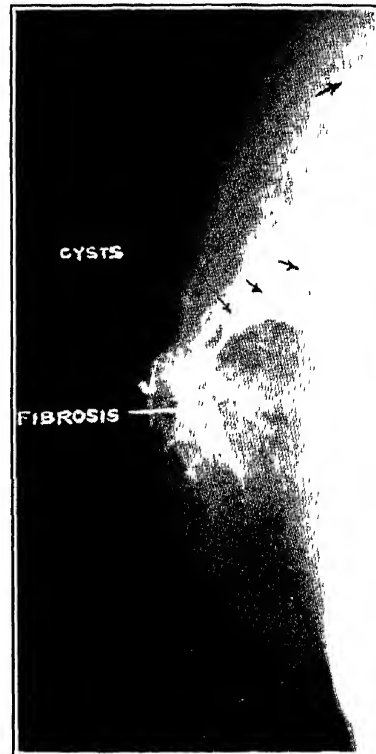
Multiple cystic degeneration of the milk ducts visualized by means of thorotrast (Am J Roentgenol, March, 1938)
